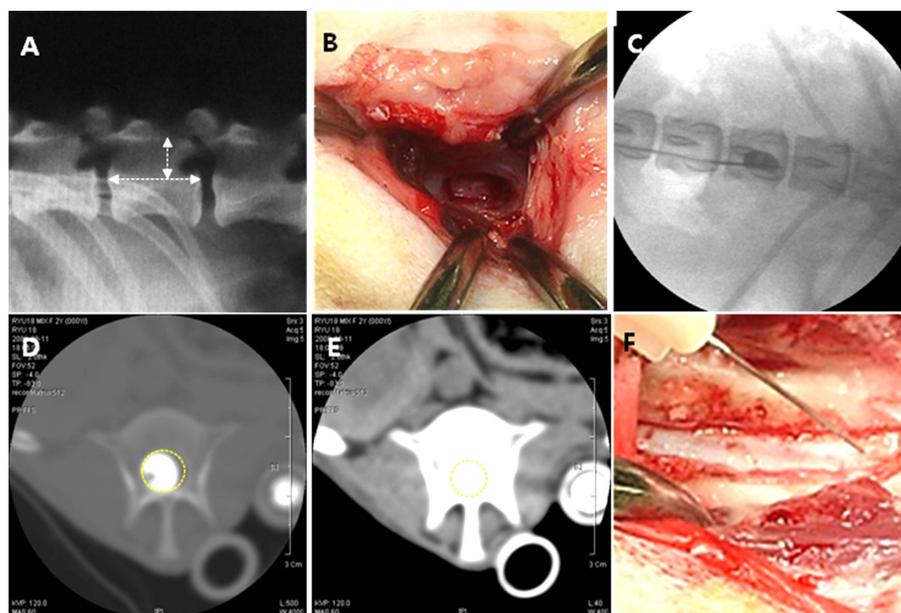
Induction of spinal cord injury (SCI) model. (A) Longitudinal axis is a length of lumbar 1 (L1) spinal canal. Vertical axis is the major axis of L1 spinal canal. (B) and (C) A 3-french embolectomy catheter was inserted into the epidural space through a left hemilaminectomy hole made in L4 vertebral arch. The balloons were inflated with a contrast agent at L1 level. (D) and (E): Transverse CT images of the epicenter of the lesion after balloon compression. The area of spinal canal in vertebra window (D) and the area of balloon inflation in spine window (E) spinal cord occlusion assessed using the formula, spinal cord occlusion ratio is the area of spinal canal in vertebra window / the area of balloon inflation in spine window × 100. (F) Transplantation of UC-MSCs after dorsal-laminectomy at L1.
